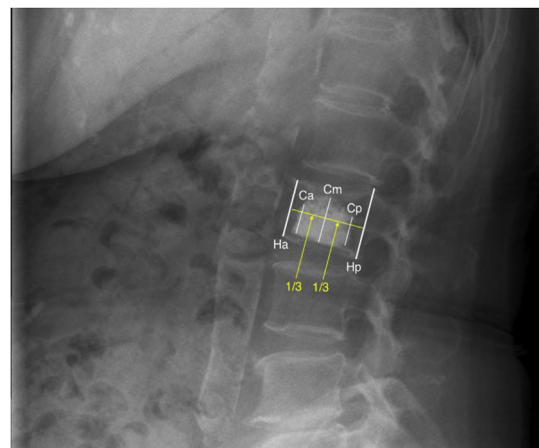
Measuring the height of bone cement and vertebra through standard erect lateral radiograph.
